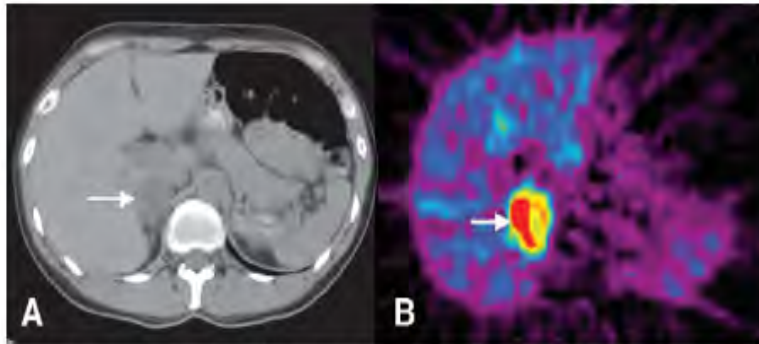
Transverse images obtained in a patient with hypertension and increased urinary catecholamine levels. A, CT image shows a 3-cm-diameter tumor in the right adrenal gland (arrow). B, HED PET image shows intense uptake within the right adrenal mass (arrow). Pheochromocytoma was confirmed at surgery.
